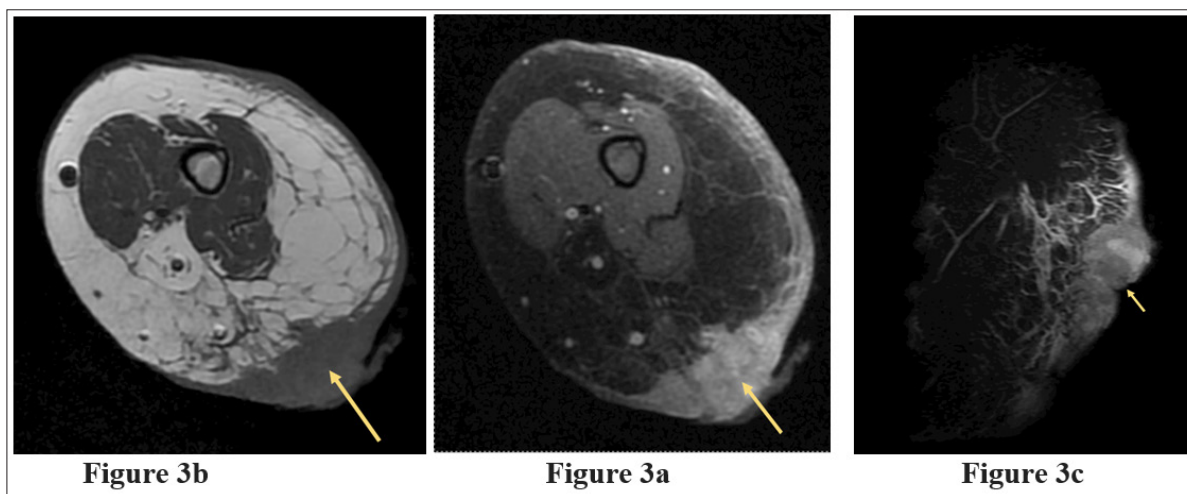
a,b,c: MRI of the left arm with and without contrast from 1/7/2023
